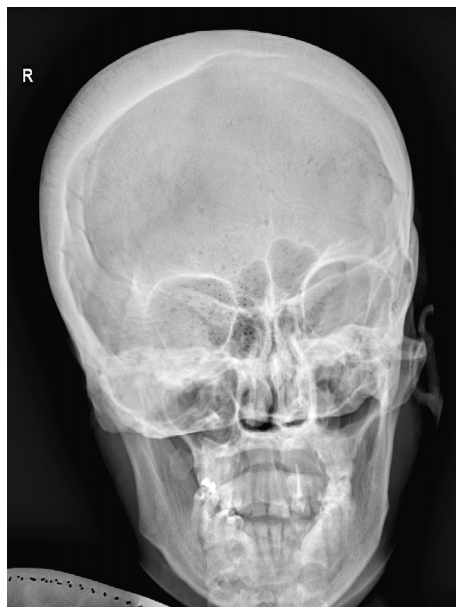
X-ray of the skull, frontal view
